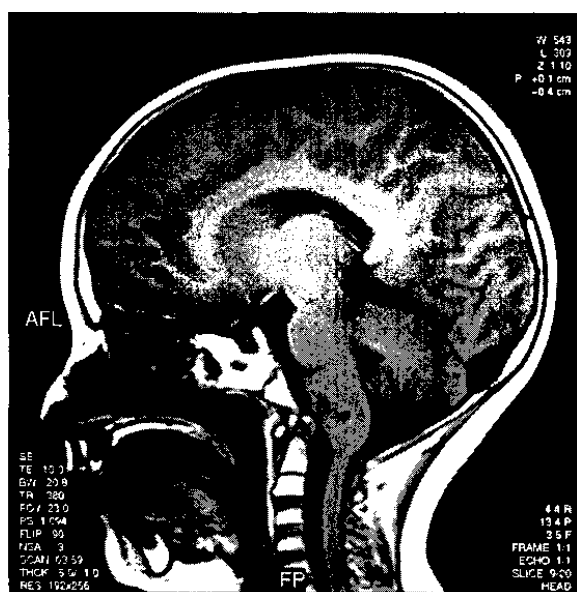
Case 5 at language testing (2 years post treatment): Sagittal T1 weighted MRI scan post radiotherapy and chemotherapy treatment for brainstem glioma. Posterior fossa structures and supratentorial structures normal with no radiation necrosis.
